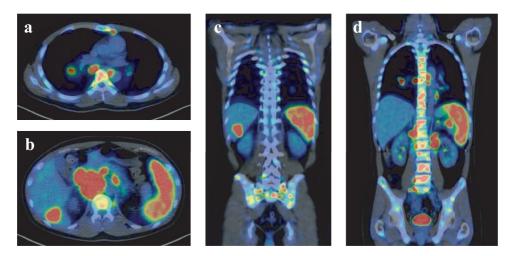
Positron emission tomography-computed tomography demonstrated pathological ¹⁸F-fluorodeoxyglucose uptake in mediastinal lymph nodes (a, d), abdominal lymph nodes (b, d), spleen (b, c, d), liver mass (b, c), and systemic bone (a, b, c, d).
